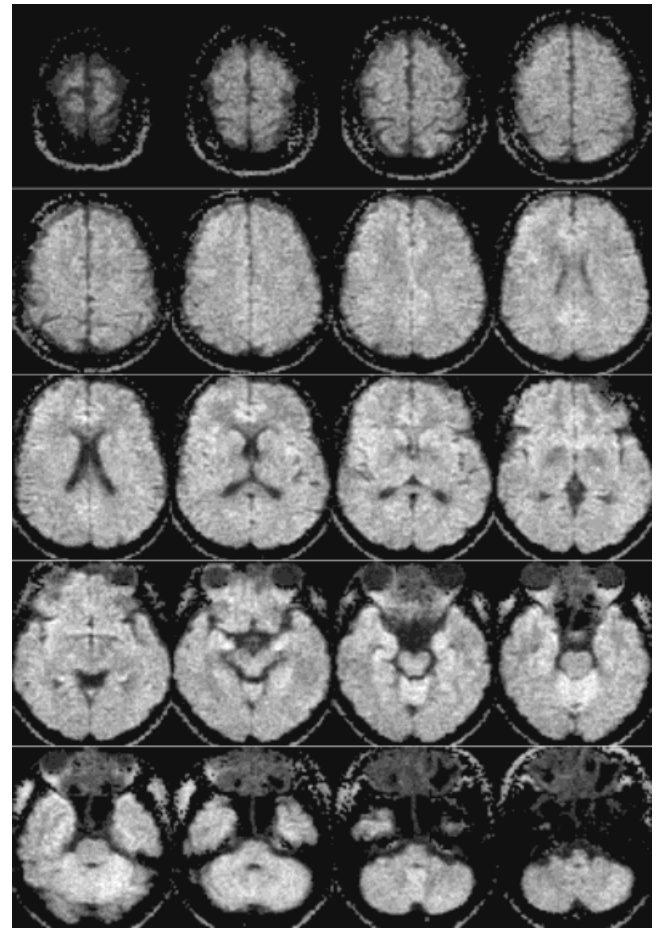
Isotropic DW STEAM MR images ( $b = 1000 \text{ sec mm}^{-2}$ ) of the human brain at  $2.0 \times 2.0 \text{ mm}^2$  resolution. The total measuring time was 78 sec for 20 contiguous sections (other parameters as in Fig. 3).
